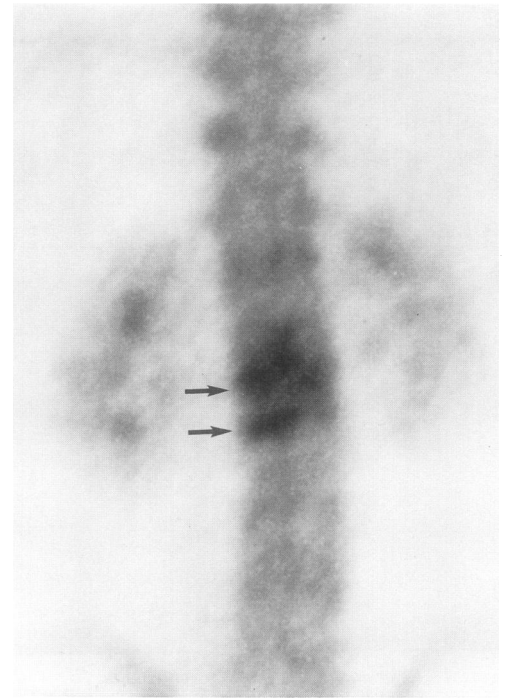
Technetium 99m bone scan (three hour image) shows two horizontally orientated areas of focal uptake at L1 and L2 vertebrae in a 25 year old man with ankylosing spondylitis (arrows). Pseudoarthrosis at this site was subsequently confirmed radiographically.
